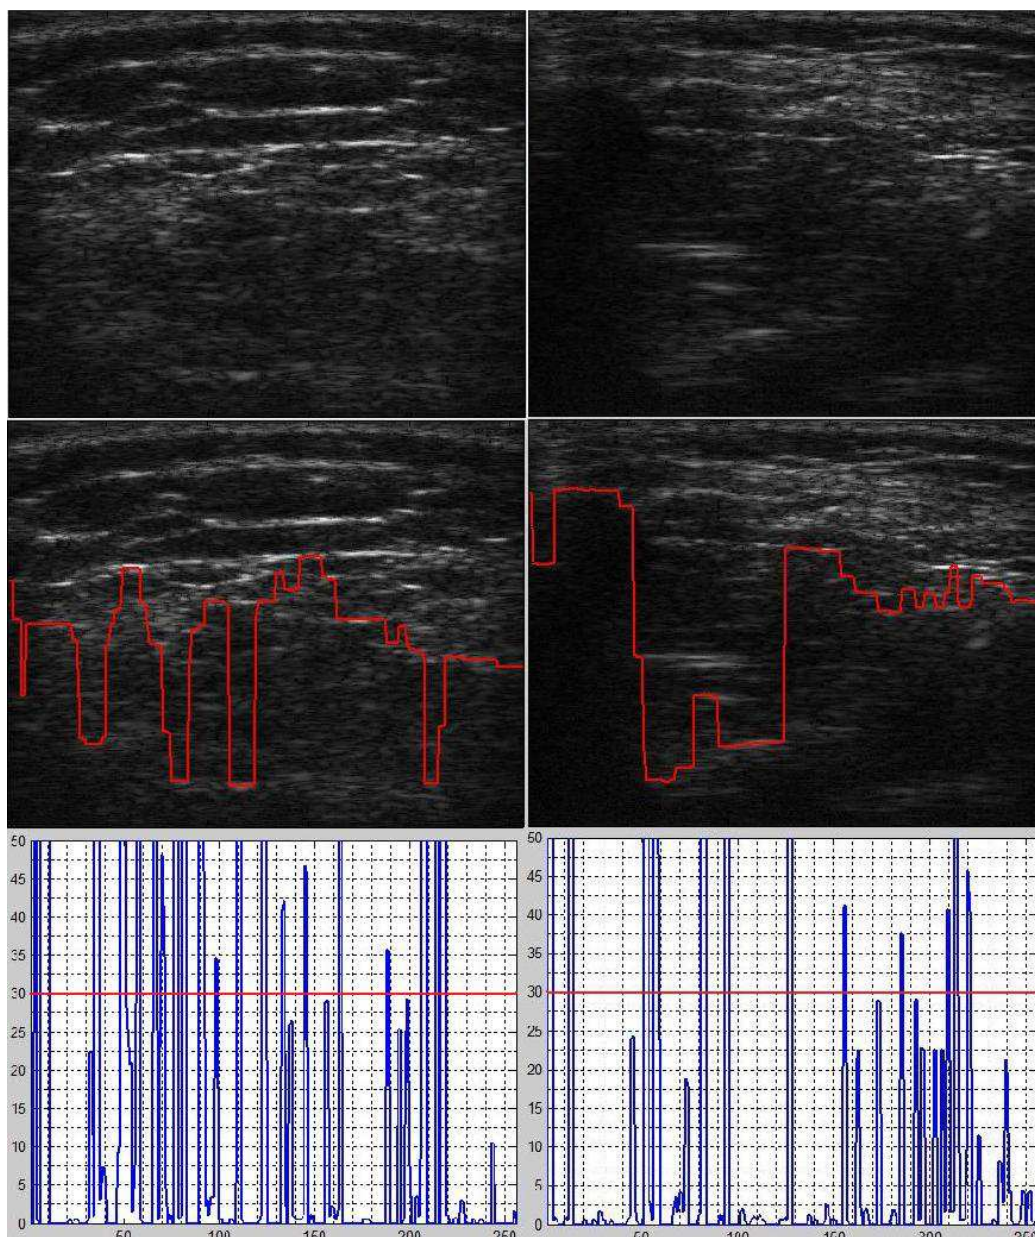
Sample ultrasound B-mode images (top) for the case of frames with no bone contour, and the extracted contour from their RF data overlaid on the B-mode images (middle), and the contour's local standard deviation with the threshold line (bottom). The entire extracted contour (red) was detected as noise since no segment in it satisfied the continuity and the minimum-length conditions
